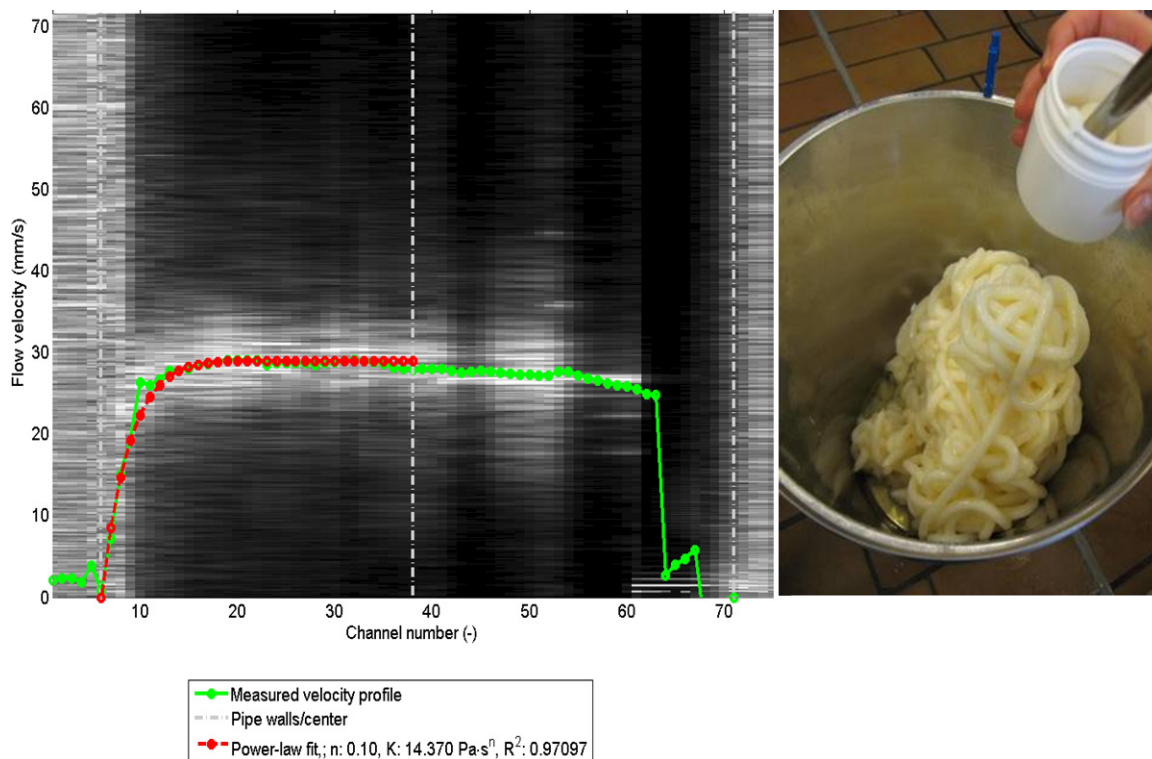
Corresponding spectral plot and ultrasound profile as an arithmetic average of 30 measured profiles (green) and resulting power-law fit (red) for the 25% Akomic / 74% rapeseed TAG and 1% CRY110 (Distilled monoglyceride) at 70 kg/h.
